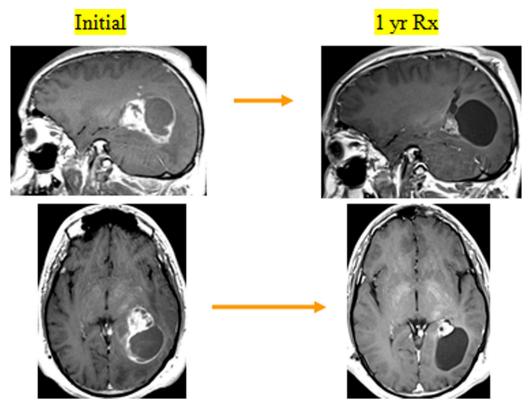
Saggital and axial enhanced MRI's of a patient on study showing a partial response after 2 months of treatment.
